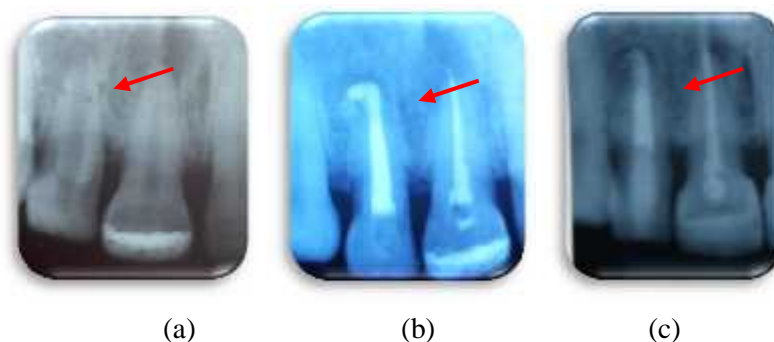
(a) Preoperative radiograph. (b) Postoperative radiograph. (c) three months postoperative follow-up
